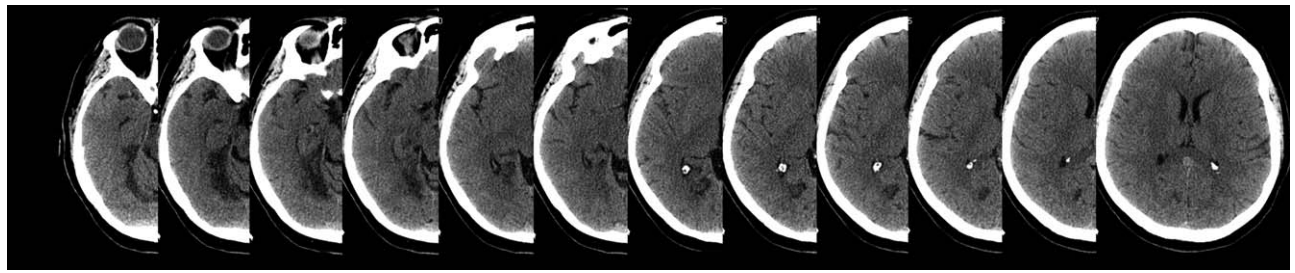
Axial computed tomographic images of the affected right hemisphere of the occipital lesion control subject.
